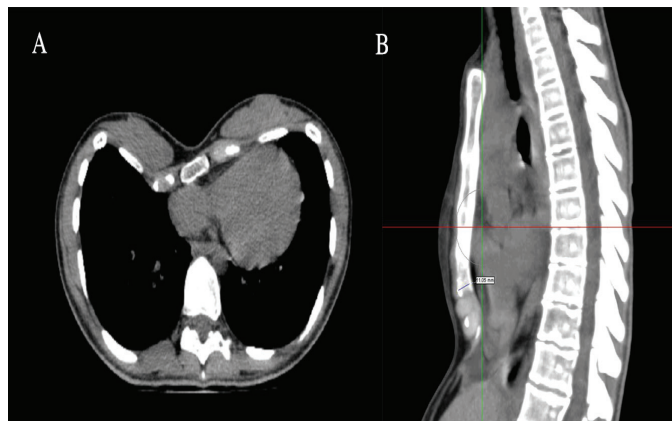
A. Preoperative Chest CT Axial Scene B. Preoperative Chest CT
